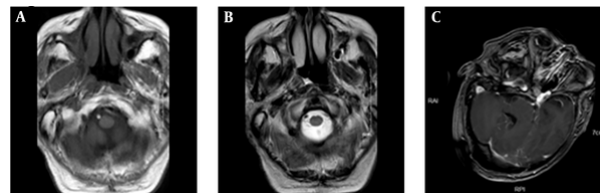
MRI images of the patient's head
